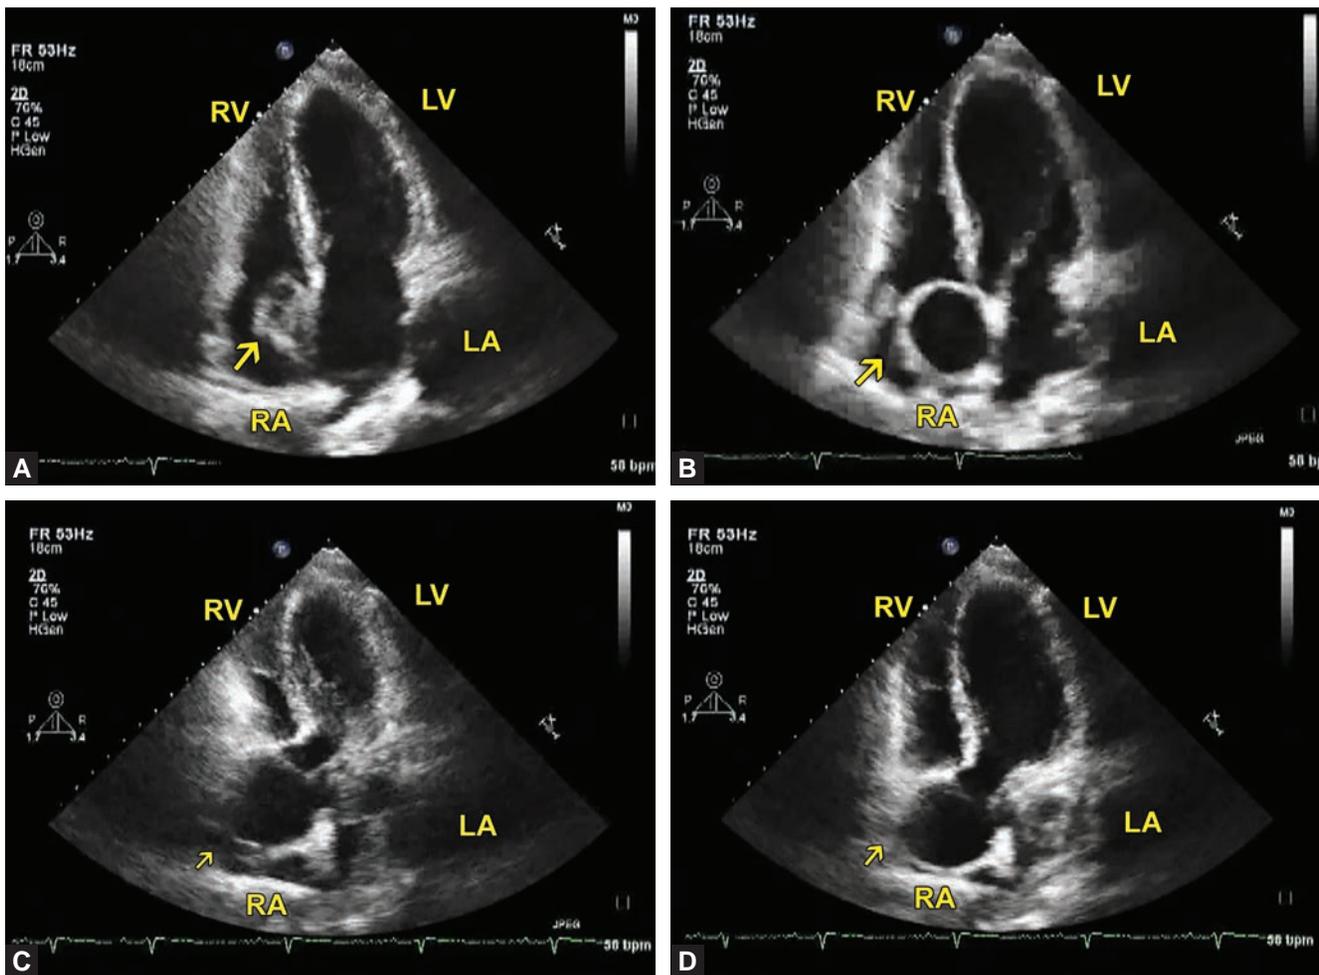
2DTTE. The arrow points to a mass in the right atrium (RA) imaged using the apical four-chamber view.
